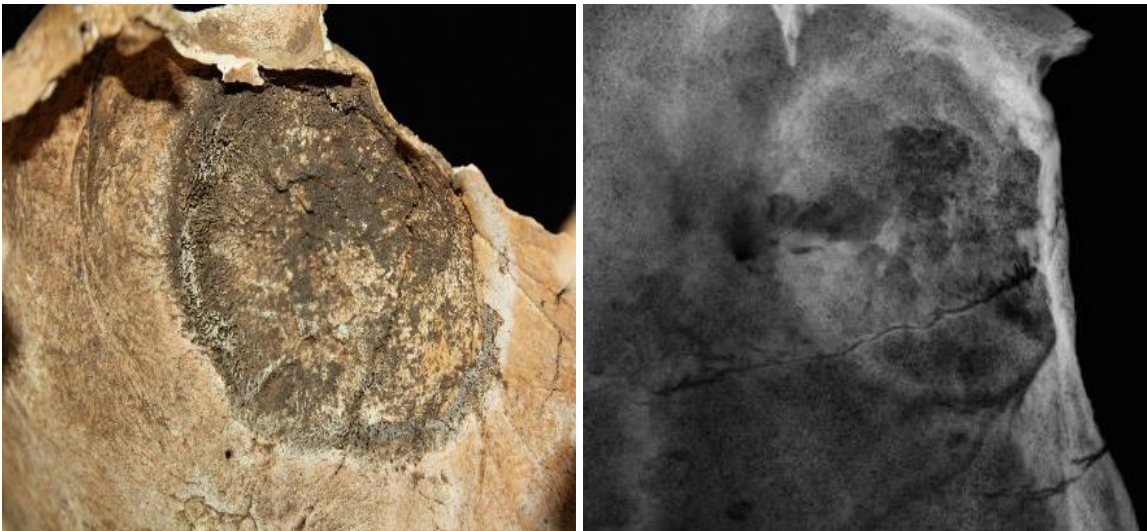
Endocranial surface of the left frontal bone (SK2192, F, 26-35 years), and comparative Xray
